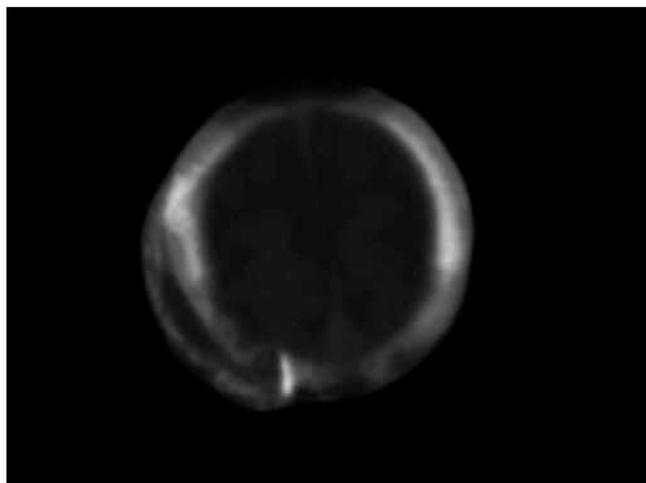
CT showed a soft tissue density mass that expanded the diploic space on the right side.
